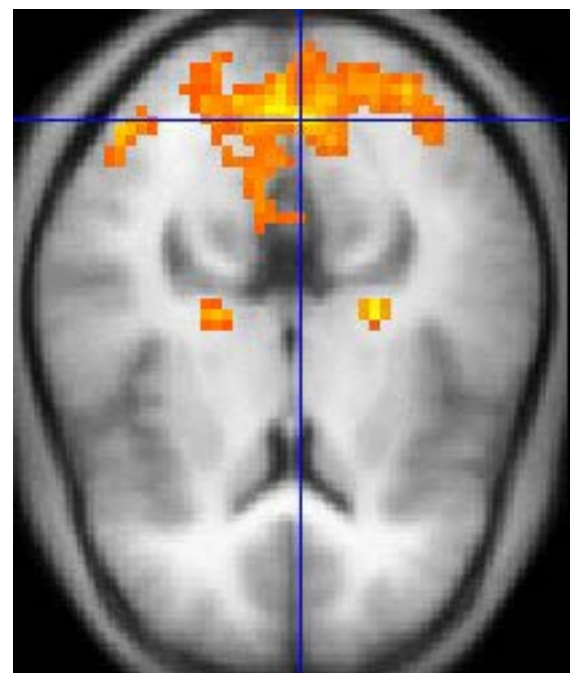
A functional MRI image showing brain activity. The warmer colours (yellow and orange) indicate an increase in blood flow. This image shows activation in the area of the brain responsible for vision.
